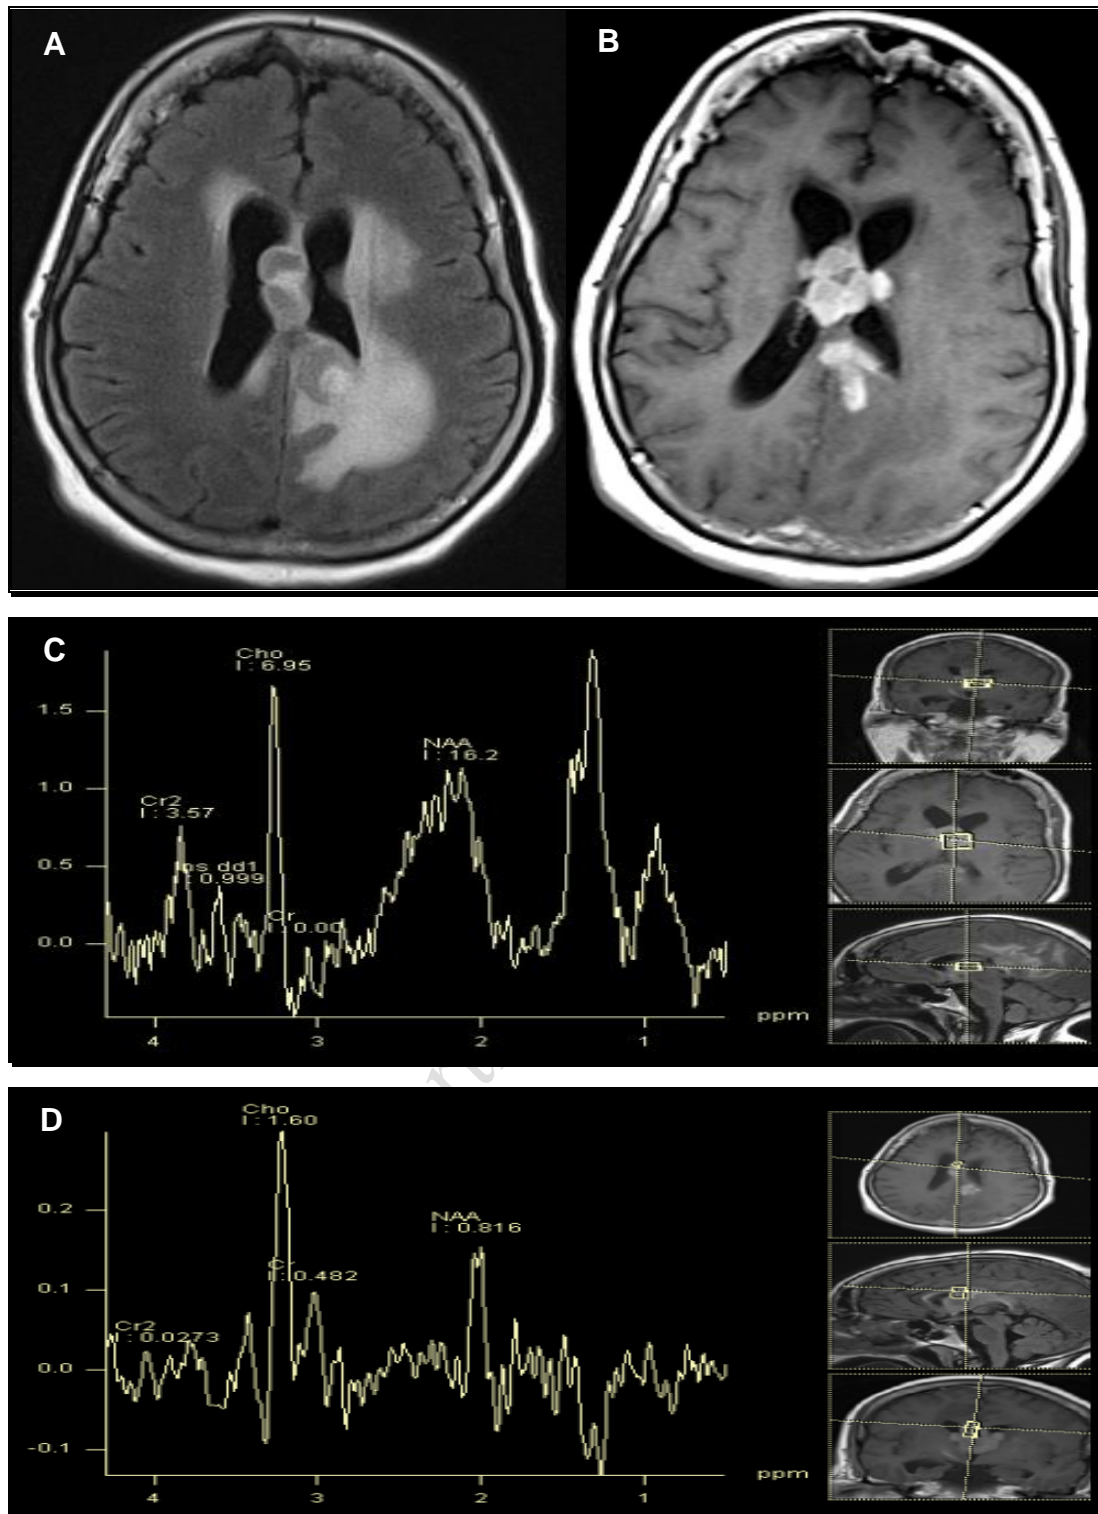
Residual tumor. Follow-up MRI and MRS study after receiving chemoradiotherapy for periventricular CNS lymphoma. Axial FLAIR (A) showing periventricular space occupying lesion involving the corpus callosum with surrounding vasogenic edema. Post-contrast axial T1 weighted image (B) showing intense enhancement of the lesion. MRS with short (C) and long TE (D) with the volume placed over the enhancing lesion showing significantly elevated choline peak, with decreased NAA and Cr peaks, and prominent lactate peak. There is elevated Cho/NAA ratio (2.12) and Cho/Cr ratio (2.9).
